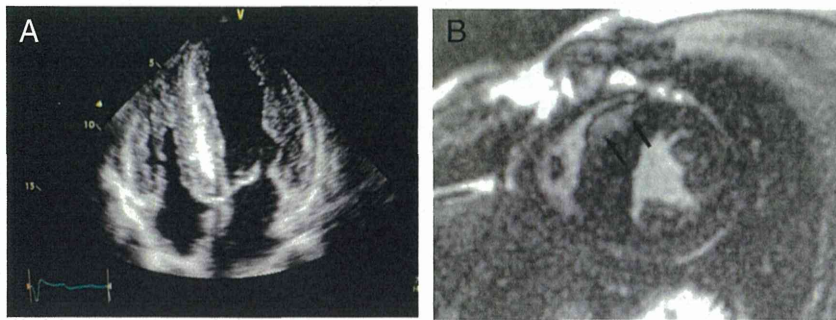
A, Echocardiographic finding. Four chamber views show symmetrical thickening of ventricular walls and septum with hyperrefractile myocardial echo (the so-called granular sparkling appearance). B, Contrast magnetic resonance imaging with gadolinium. Focal late gadolinium enhancement is visible (arrows).
